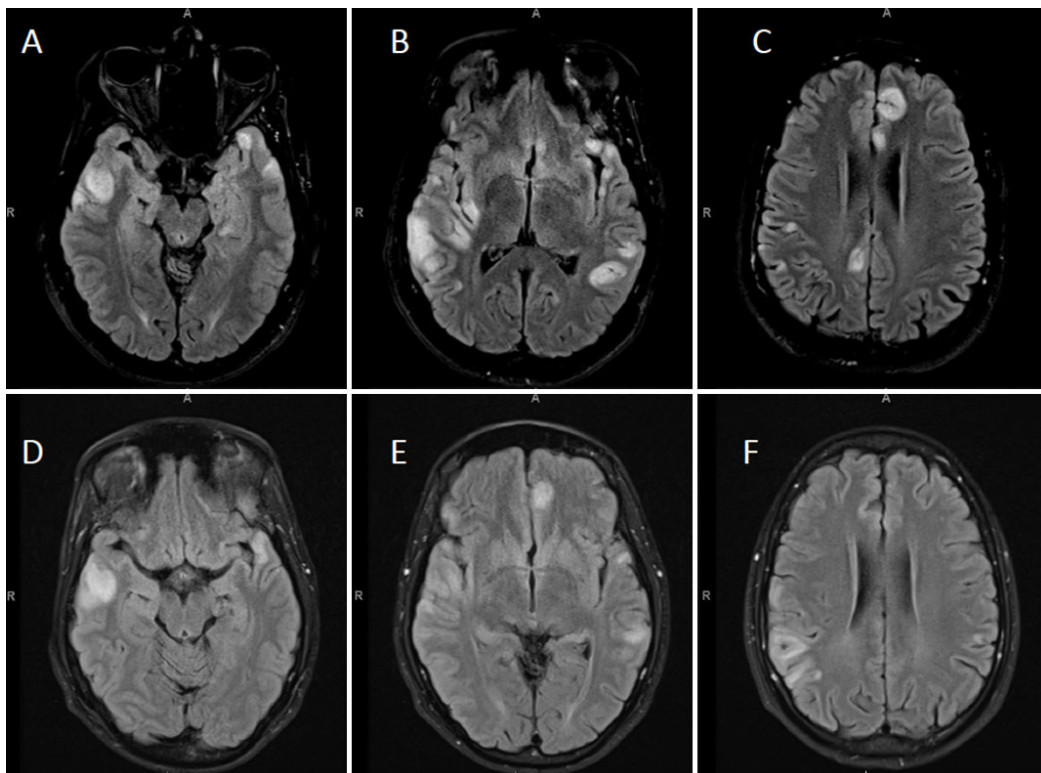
Initial and follow-up magnetic resonance imaging brain scans showing multiple cortically-based signal abnormalities. Images A-C are axial fluid-attenuated inversion recovery images showing multifocal elevated cortical T2/FLAIR signal intensity with associated swelling with involvement of the adjacent subcortical white matter from patient's initial presentation. There was no contrast enhancement, and there was no definite involvement of the deep gray structures, brainstem, or cerebellum. Images D-F are follow up images approximately two weeks later that reveal overall improvement, for instance, previously seen abnormality along the medial left frontal lobe, and in the posterior right insular lesion improved
